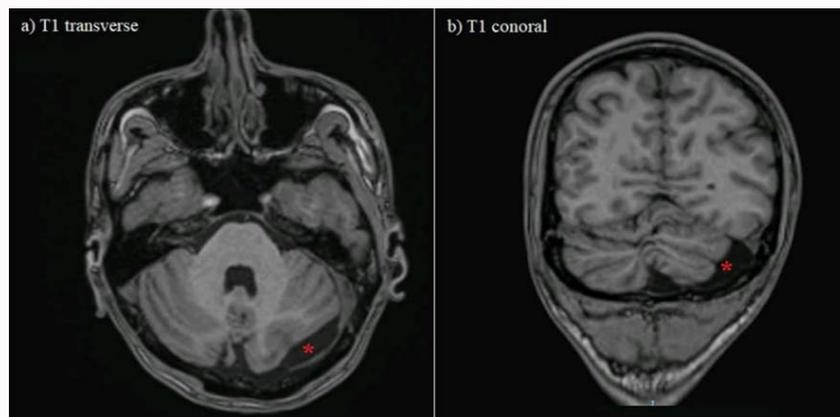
Cranial MRI images in transverse (a) and coronal (b) planes, showing the cyst in the retrocerebellar location (*).
